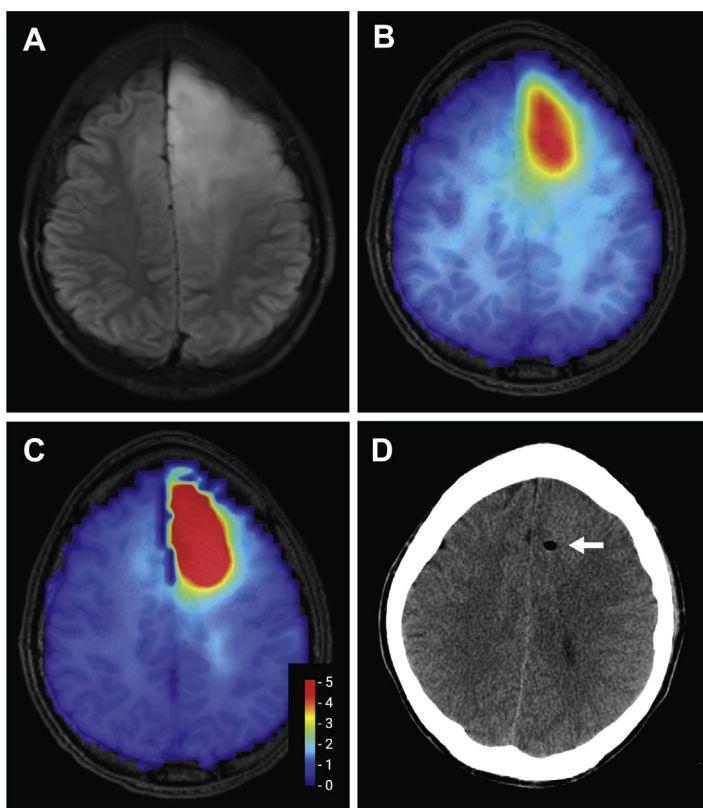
Grade 3 astrocytoma. A 31-year-old man with a left frontal expansile, nonenhancing mass seen on FLAIR (A). T1-weighted images overlaid with 3D Cho map (B) and Cho/NAA ratio (C), showing areas of greatest metabolic abnormality. Scale in (C) shows the ratio between Cho/NAA and normal white matter. Stereotactic biopsy was targeted to a region with maximal metabolic abnormality, as seen on post-biopsy CT (D).
